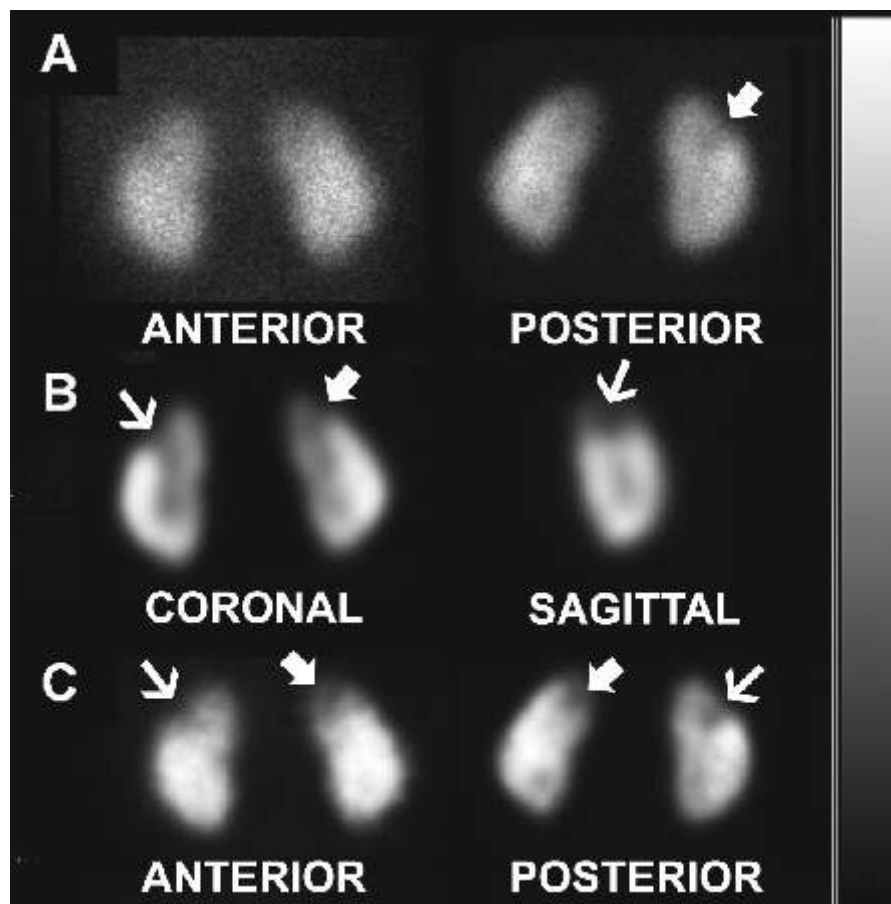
Tc-99m DMSA planar (Top row), SPECT (Middle row) and planar filtered (Bottom row) scans. A cortical defect in the right kidney (Thick arrow in top row) is faintly visualized on the posterior view of the planar images (A). The defect is more clearly visualized on SPECT (B) and filtered (C) images (Thin arrow in middle and bottom rows). Another defect in the left kidney (Thick arrow in middle and bottom rows) is seen only on SPECT and filtered images.
